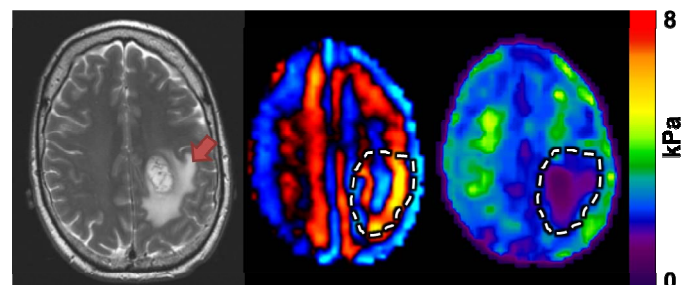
Grade IV – Glioblastoma. (Left) Axial Gadolinium-enhanced T2-weighted image. (Middle) MRE wave image. (Right) Elastogram, or stiffness map.
